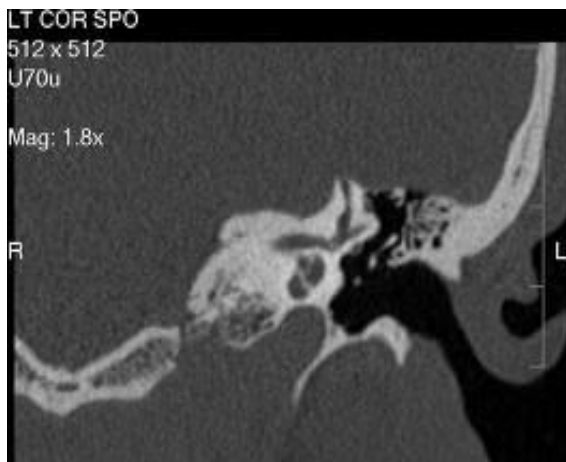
CT scan image of mastoid bone shadow in right hilum with increased broncho-vascular markings. Pus aspirated from pre-auricular
